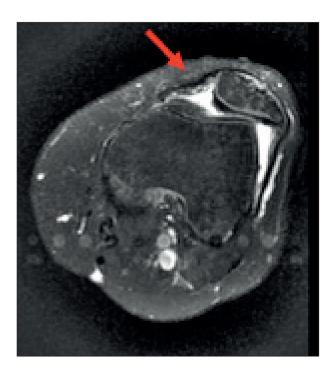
Left Knee MPFL injury of a 34years old man. A transverse T2-FSE MR image of the knee shows attenuation of signal of the MPFL.
